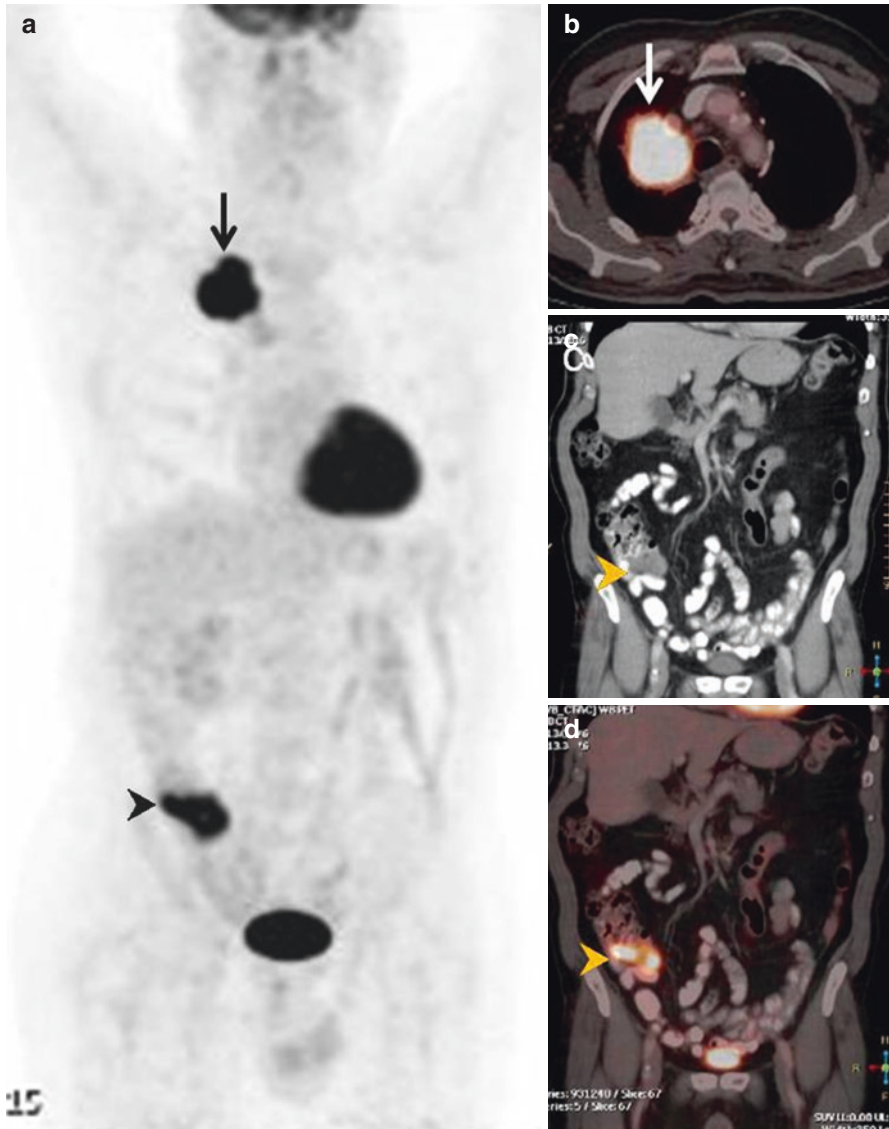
Whole body MIP image and fusion PET/CT images show a FDG-avid mass in the right lung (arrows in a, b). Focus of FDG avidity in the lower abdomen seen in the MIP image (arrowhead in a) corresponds to a second primary malignancy in the cecum on coronal CT and fusion PET/CT image (arrowhead in c, d)
